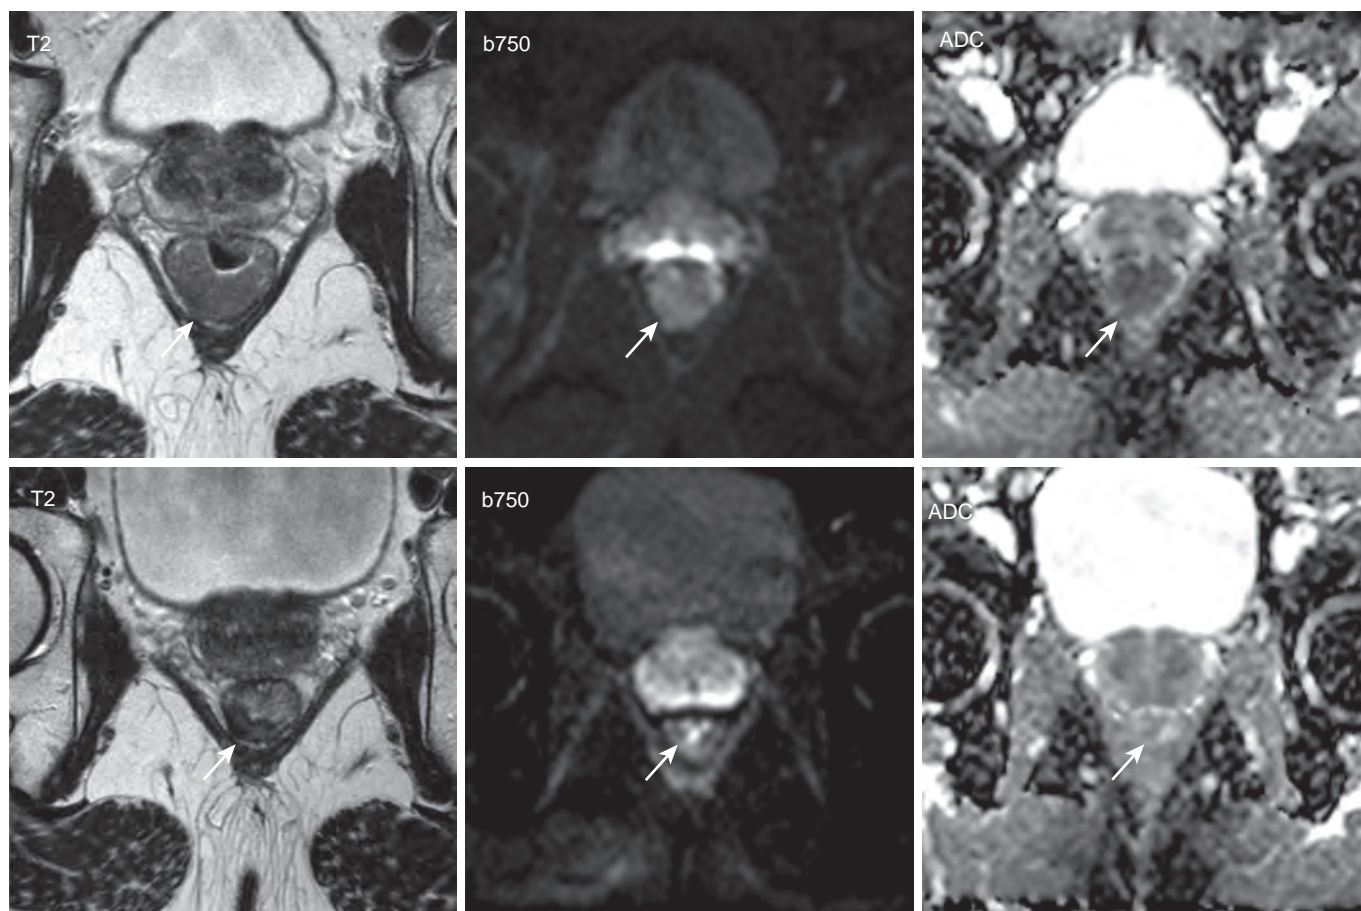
Changes in diffusion-weighted imaging in response to treatment. *Top panel,* Pretreatment appearance of the distal rectal adenocarcinoma (arrow). The primary tumor is hyperintense on diffusion-weighted imaging (b750) and hypointense on the apparent diffusion coefficient (ADC) map, indicating restricted diffusion. *Bottom panel,* Appearance 3 months after chemoradiotherapy. The tumor shows marked hypointensity on the T2-weighted image, indicating fibrosis. The mass is isointense to the surrounding rectal wall on diffusion-weighted images, as would be expected for response due to loss of cellularity.
